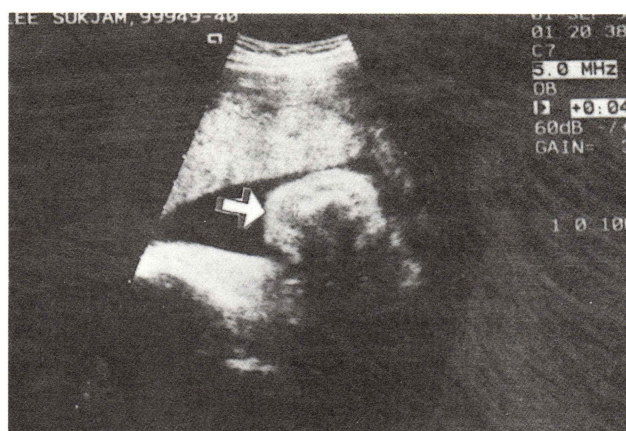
Ultrasound image of phocomelia.
